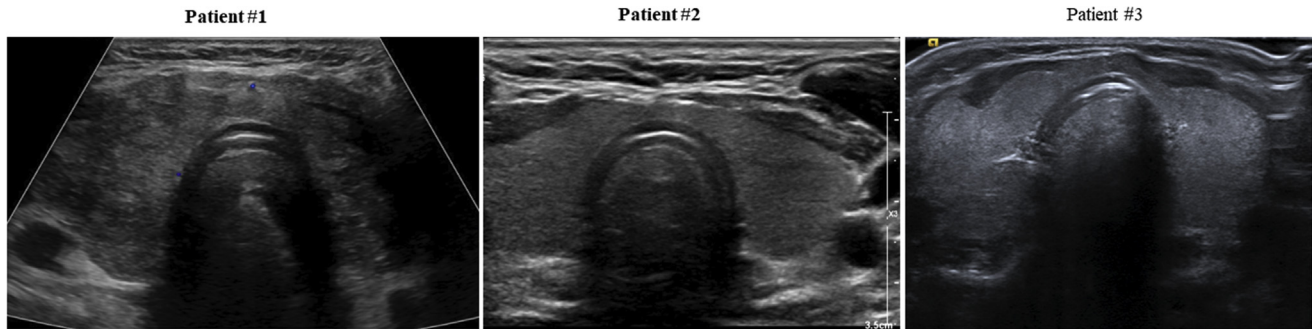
Transverse ultrasound images of the thyroid gland of the 3 patients showing a heterogeneous and enlarged thyroid gland without nodules.
